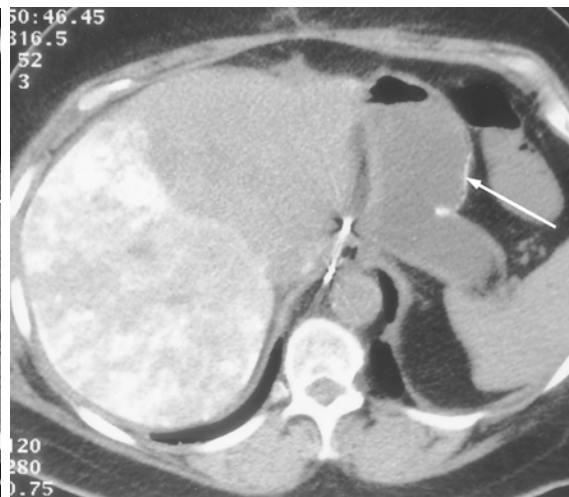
(12) Nonenhanced CT scan shows gastric deposition of chemoembolization material with ethiodized oil (arrows) following the line of the gastric mucosa. (13) Nonenhanced CT scan shows calcification of the gastric wall (arrow). The calcification was caused by radiation therapy for renal cell carcinoma many years earlier. (14) Nonenhanced CT scan shows hyperattenuating areas in the lumen of the stomach due to ingestion of milk of magnesia (arrow).
